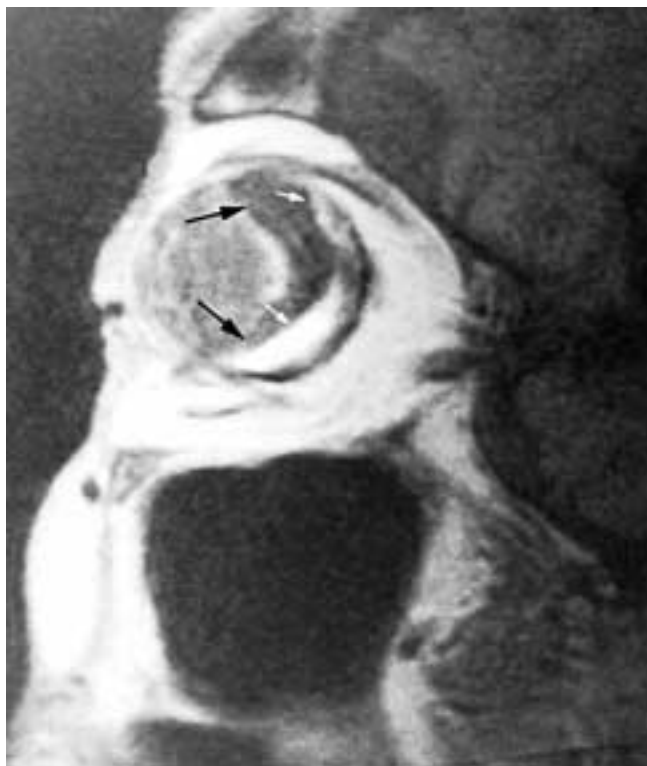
Posterior hyaloid detachment and retinal detachment in a patient with complicated macular degeneration. Sagittal T1-weighted MR image shows two semilunar regions; the posterior region (*white arrows*) is caused by chronic subretinal hemorrhage, and the anterior region (*black arrows*) is caused by posterior hyaloid detachment. Surgery confirmed these findings.
